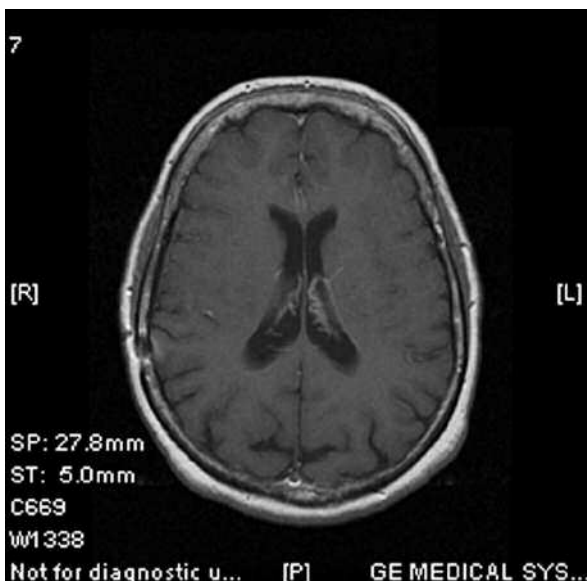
Current control T1-weighted MRI axial images with contrast enhancement
